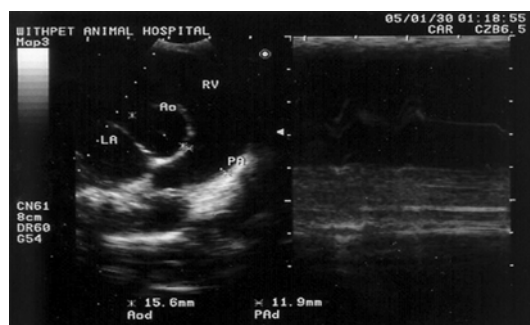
Ultrasonographic finding of PDA patient.
